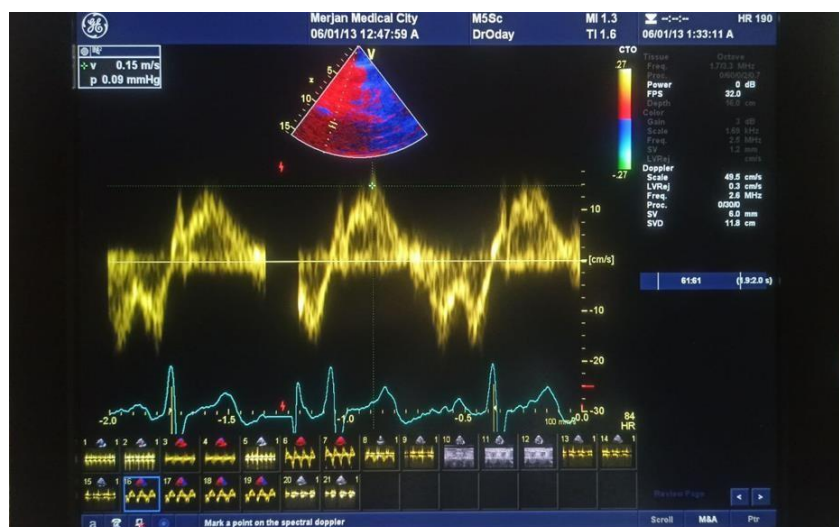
TDI, PW Doppler for measurement of RV free wall S'.
